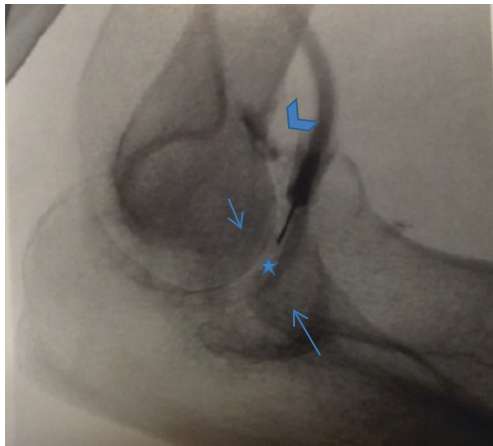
X-ray elbow injection technique lateral approach. Radiocapitellar joint is parallel to the beam and open without no parallax (*arrows*). Target point is central in de joint (*asterisk*). The needle is inserted vertical intra-articular. Contrast flow away from the tip of the needle (*arrowhead*)
